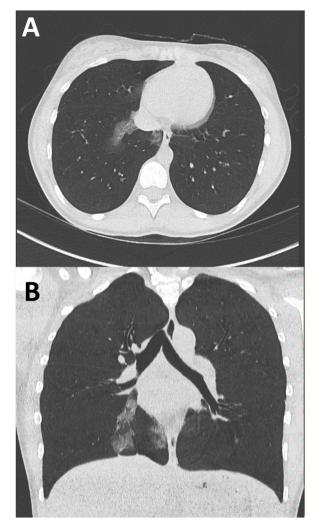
Axial (A) and coronal (B) chest CT scan. The scan shows asymmetric, unilobar, central patchy ground glass compatible with Covid-19 pneumonia.
